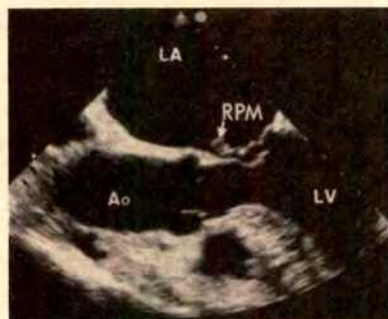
Transesophageal echocardiogram shows a ruptured papillary muscle (RPM) (arrow) attached to the posterior leaflet of the mitral valve in the left atrium (LA) during systole. Ao = aorta; LV = left ventricle.
